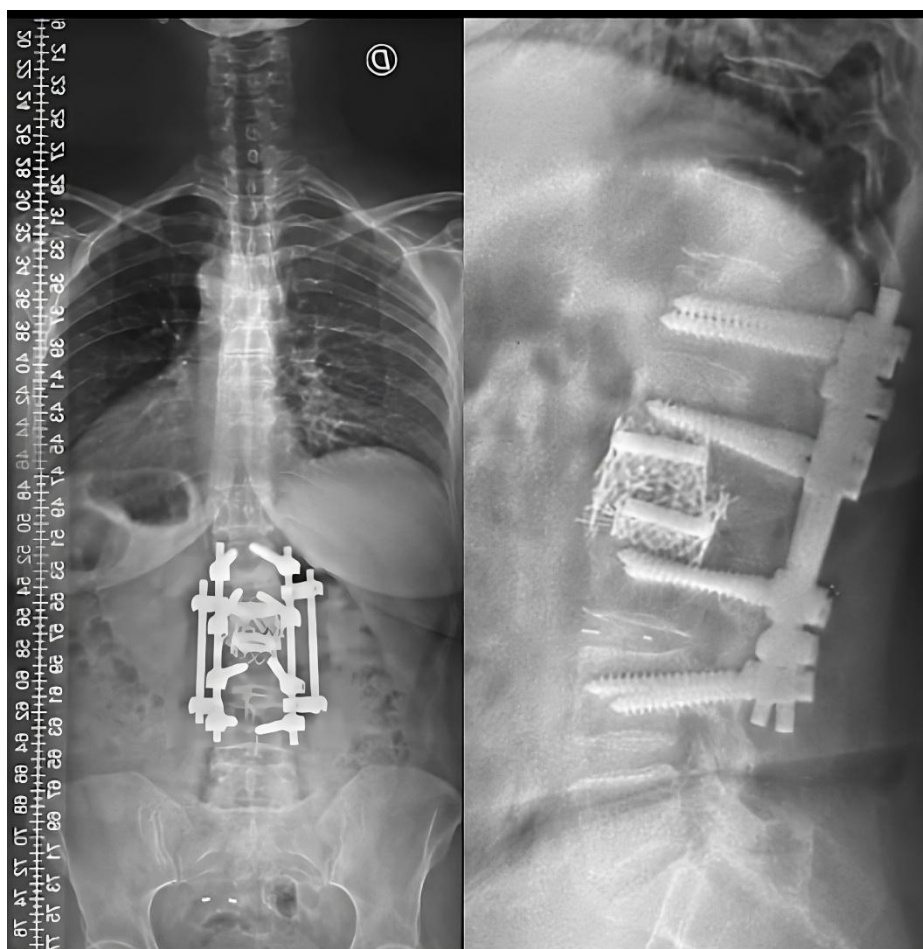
1-year postoperative anterior-posterior and latera lumbosacral X-ray showing revision surgery and no related mechanical complications.
